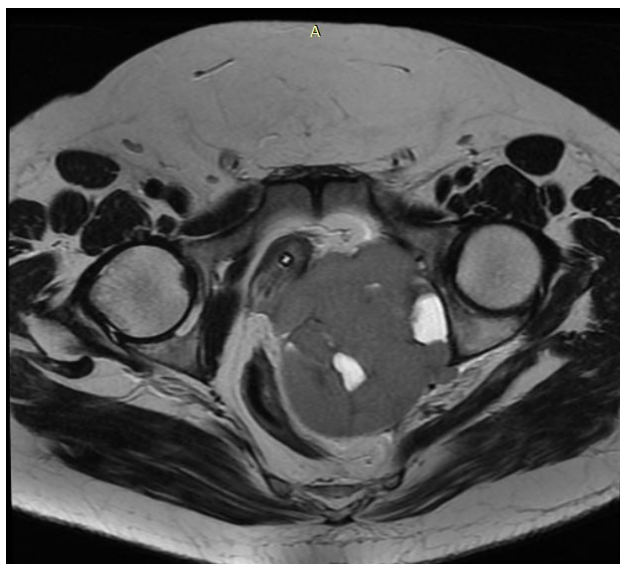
pelvic MRI axial T2 sequence without gadolinium
